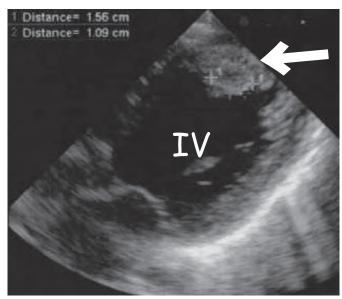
Patient 3. Apical 4-chamber echocardiogram showing dilated left ventricle with apical thrombus (arrow).
